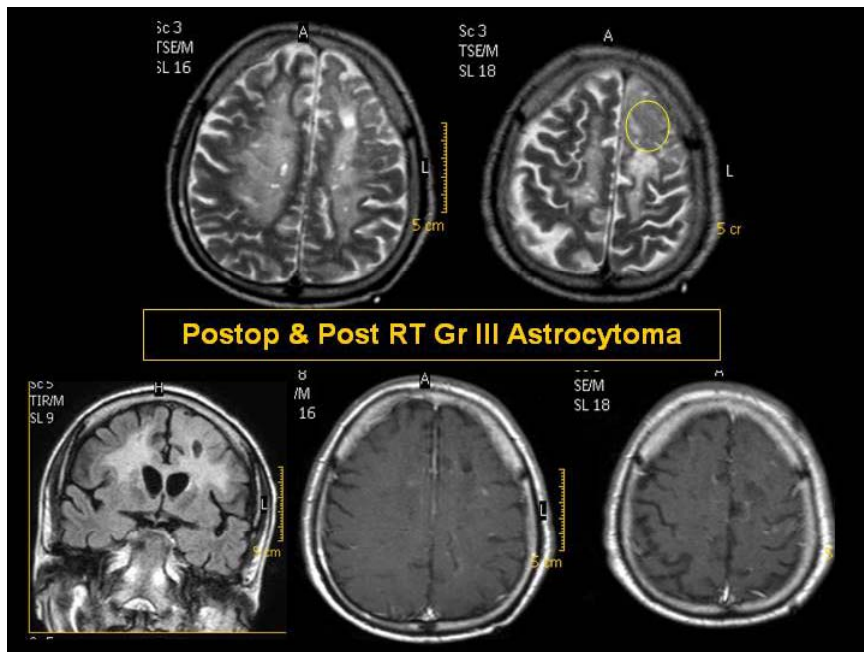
MRI shows signal alteration on T2 WI in deep white matter bilaterally representing post radiation leuko-encephalopathy
